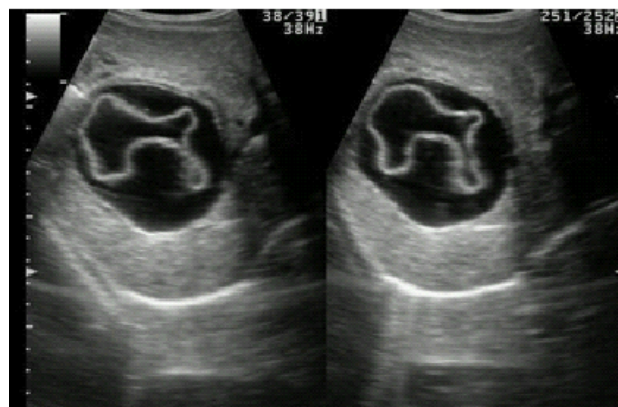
Hepatic hydatid cyst - ultrasound water lily sign (Radiopedia)
